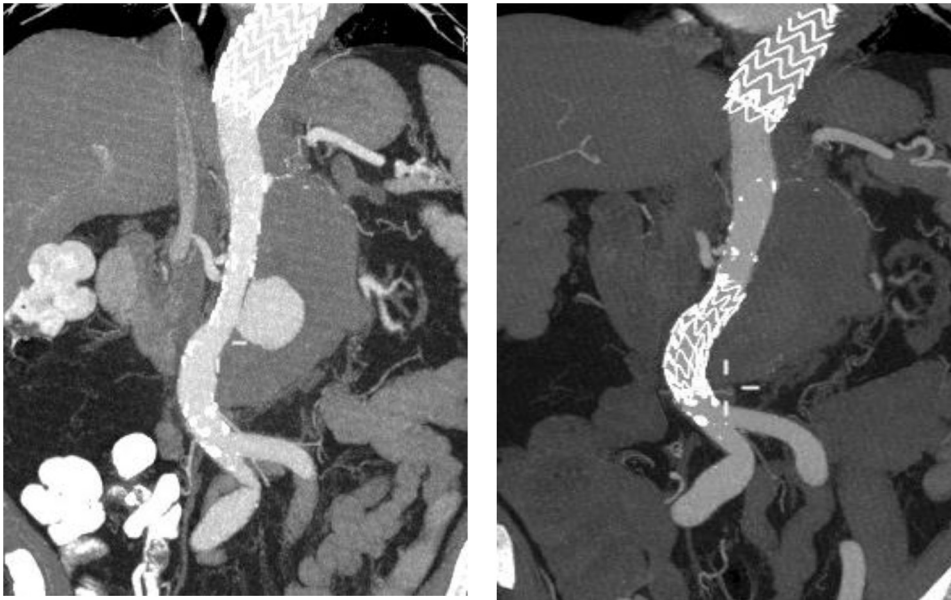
Patient A. Left box: computed tomography angiography (CTA) 6 years after thoracic endovascular aortic repair (TEVAR) showing new entry tear at the infrarenal aortic segment associated with rapid aneurysm expansion that required urgent treatment with straight
